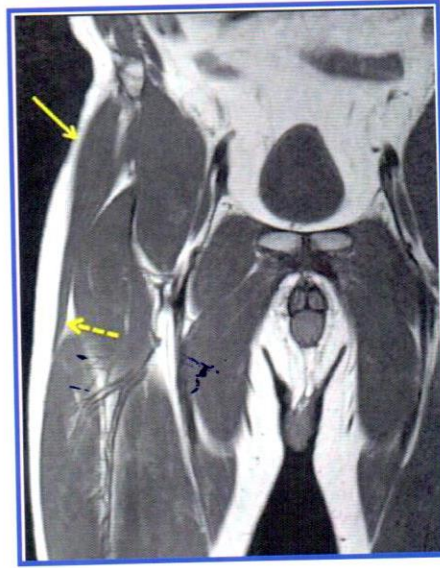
T1-weighted coronal MR image. The arrow shows the belly of the tensor fascia lata muscle. The dashed arrow shows the distal part of the muscle before insertion.
